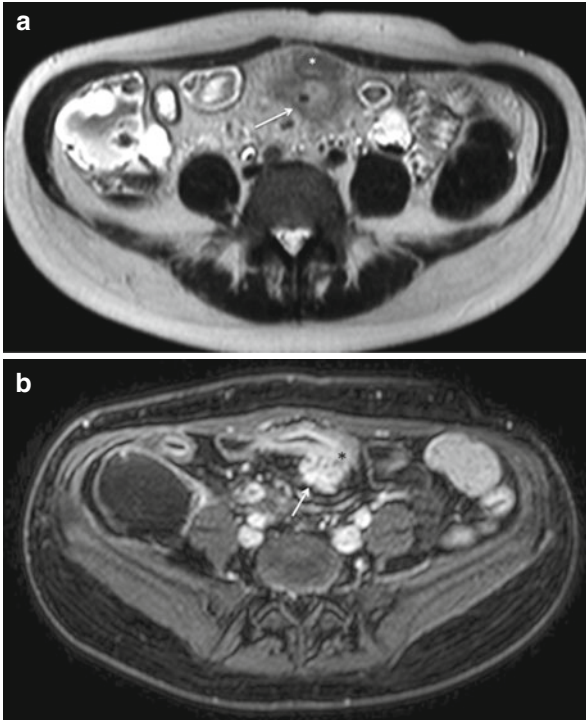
Enterosigmoid fistula with perivisceral abscess. Axial HASTE images (a, c) and axial GE T1-weighted fat-saturated images, performed after i.v. injection of gadolinium (b, d) obtained along two different axial abdominal planes. (a, b) show an enterosigmoid fistula (*arrow*). (c, d) depict a small abscess in the adjacent mesentery, just below the fistula (*arrows*). Note also the “target sign” in the adjacent diseased bowel segment (c, d)
